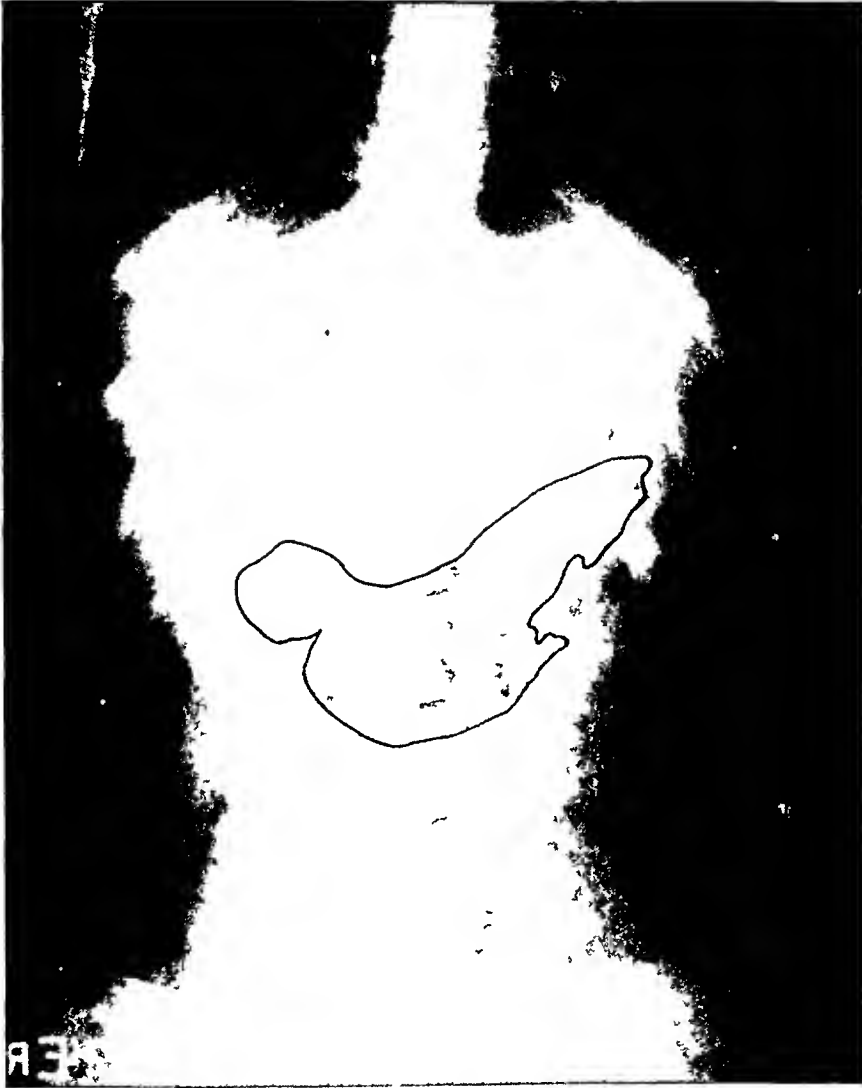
Preoperative plain film of abdomen of Case 1, showing the left diaphragm and stomach outlined with India ink Note downward displacement of gas filled stomach and serrated greater curvature
